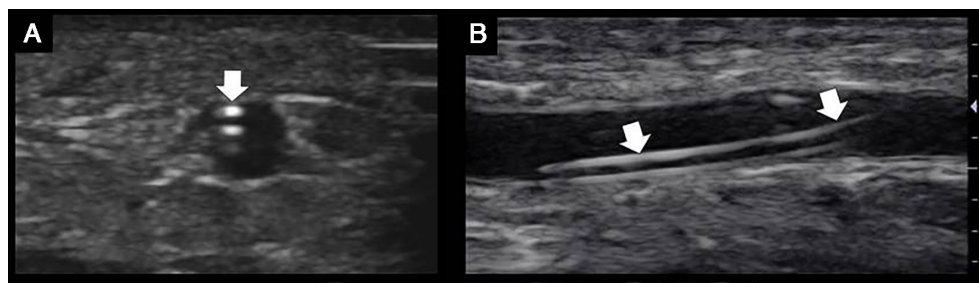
An ultrasound picture out-of-plane (A) and in-plane (B) view of a peripheral intravenous catheter (PICV) located inside of the vein. Reproduced with permission from Ref 30.
